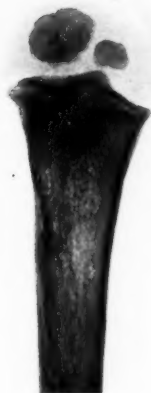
A. P., 1135. X-ray picture of the upper end of the humerus. The outer corner shows a minute spot of rarefaction.
